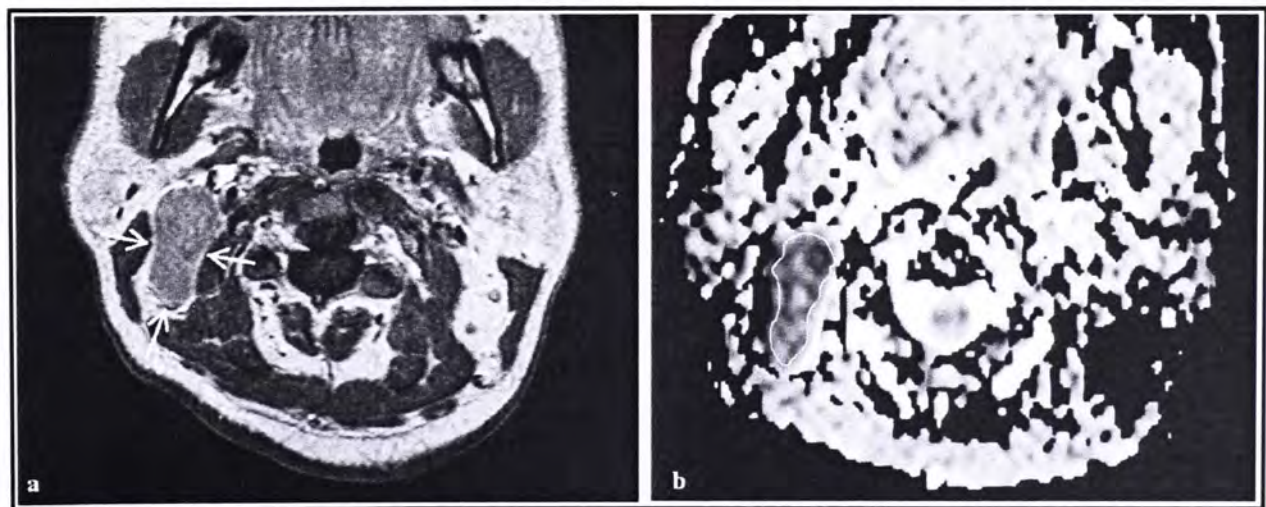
Post-contrast T1-weighted image (left) with the malignant node (arrows) and ADC map (right) with the region of interest drawn around the malignant node.
